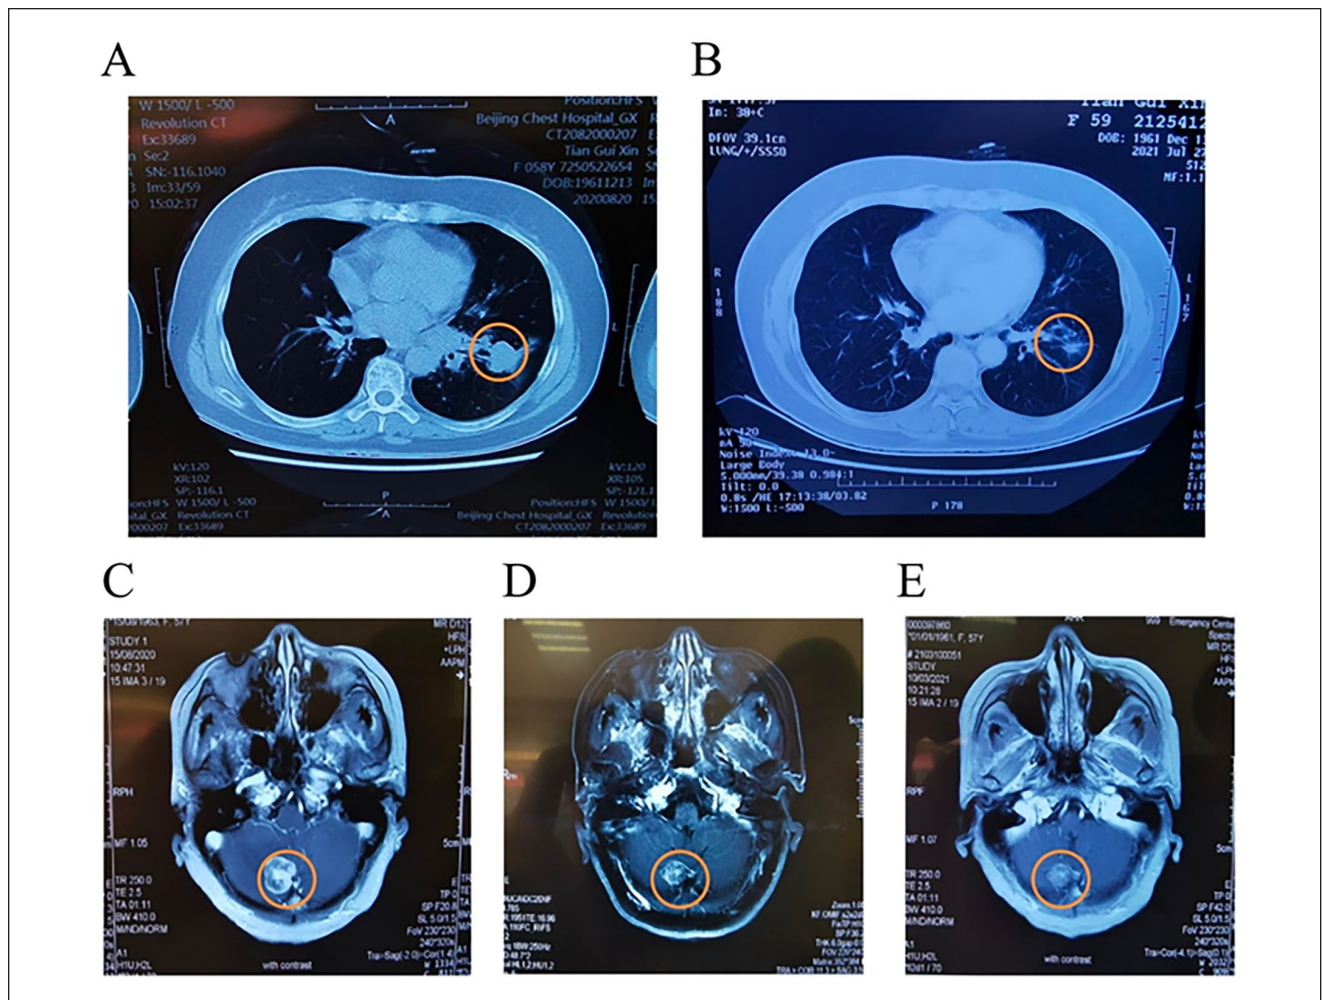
Comparison of examination indexes before and after treatment in a lung cancer patient. (A) Lung enhanced CT in August 2020. (B) Lung enhanced CT in July 2021. (C) Brain enhanced CT in August 2020. (D) Brain enhanced CT in March 2021. (E) Brain enhanced CT in July 2021.
